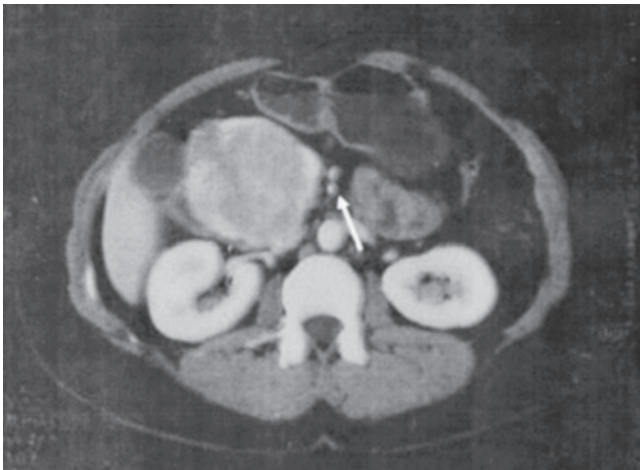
Abdominal CT of a large cystic mass with solid components arising from the head of the pancreas and extending into the root of the mesentery along the mesenteric vessels (*arrow*). The partially solid nature of the tumor raised concern of a malignant pancreatic tumor; however, at exploration the mass was found to be well localized and easily separable from surrounding structures. A pylorus-preserving pancreaticoduodenectomy was performed; final pathology showed a 7-cm serous cystic neoplasm.
